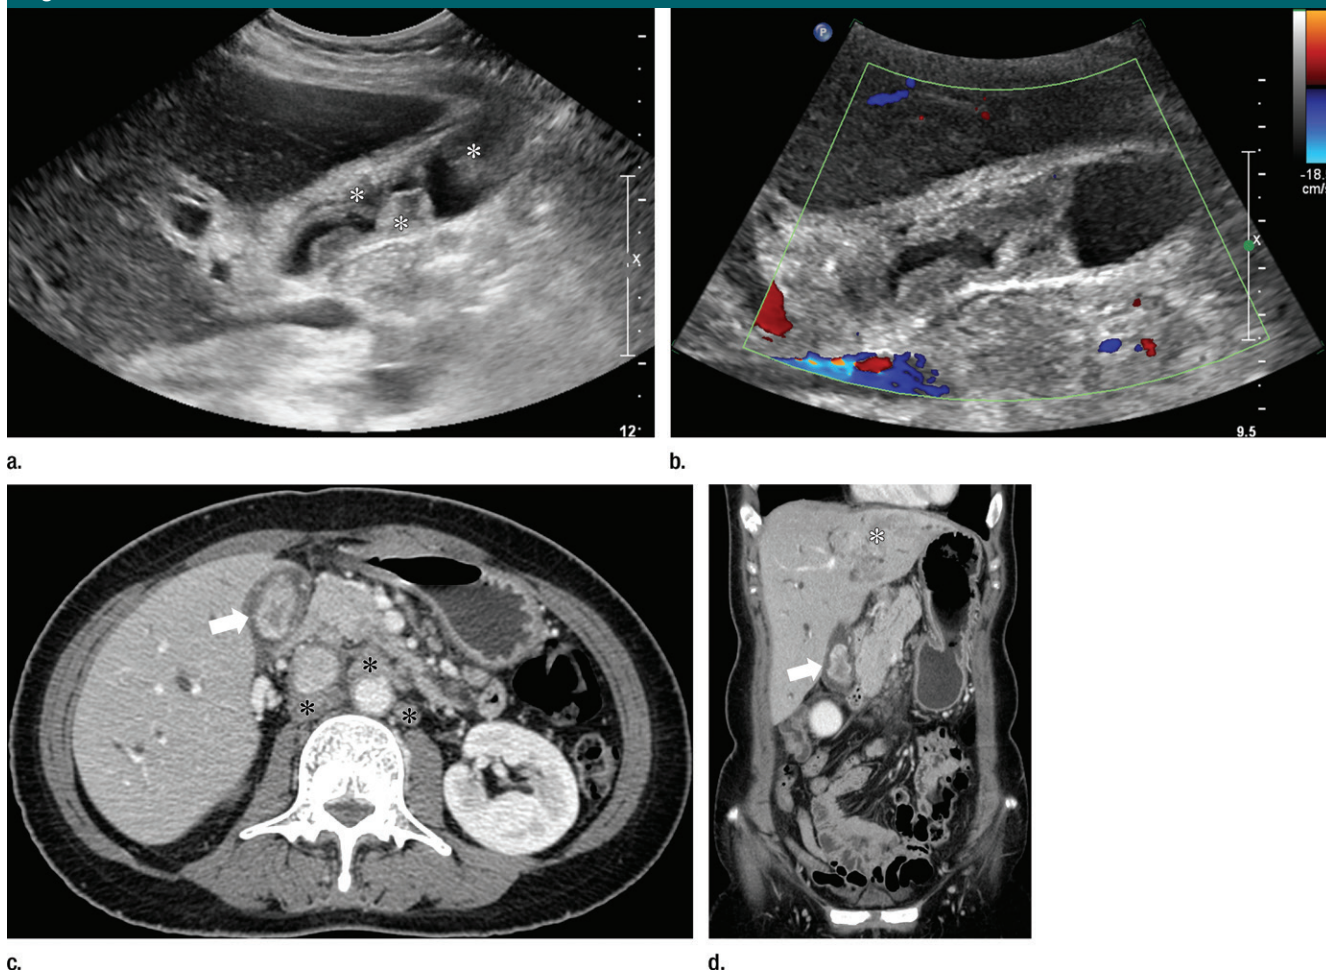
Images in a 45-year-old woman with inoperable malignant tumefactive sludge. (a) On B-mode US image, multiple heterogeneous echogenic masses without movability are located in body to fundus of gallbladder (*). (b) On color Doppler US image, these lesions do not have internal vascularity. Follow-up (c) axial and (d) coronal CT images show irregular thickening gallbladder inner wall with prominent enhancement (arrow). There are multiple metastatic lymph nodes in the retroperitoneum (*, c) and hepatic metastasis in left lobe (*, d). The patient underwent palliative chemotherapy for advanced gallbladder cancer.
